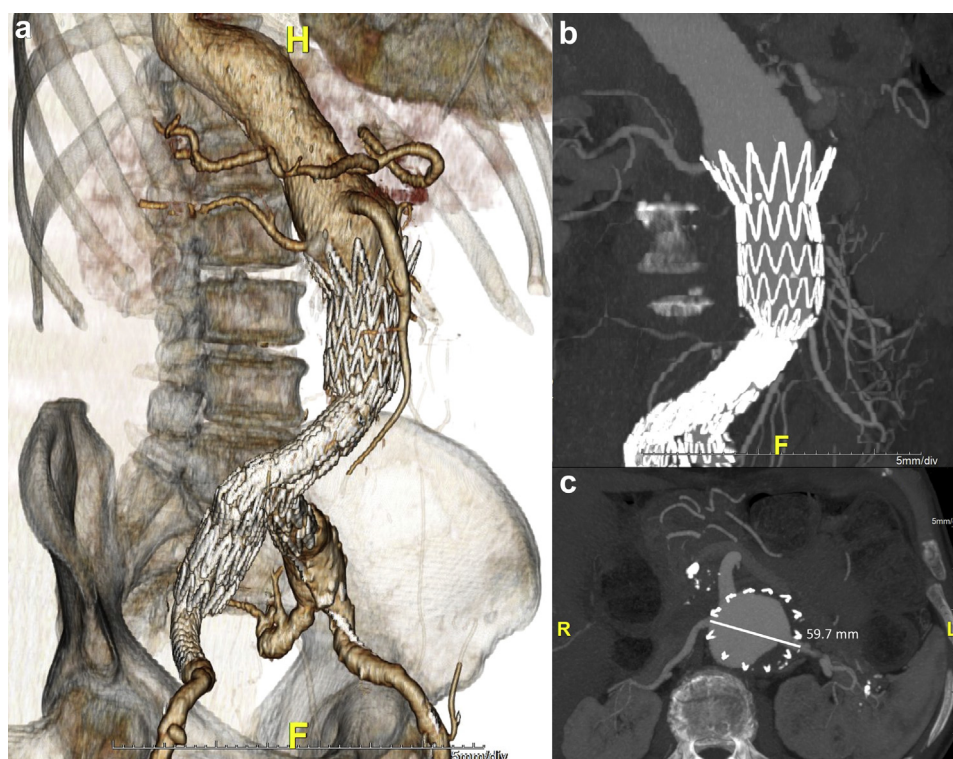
Computed tomography (CT) scan control in a patient that developed recurrent proximal aortic aneurysm in the visceral segment with subsequent distal migration; a, Three-dimensional reconstruction; b, Maximum intensity projection in coronal; and c, Axial view.
